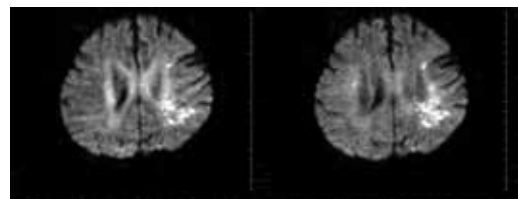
Figure shows the acute ischemic stroke image in different MRI sequence at 48 hours after onset.
